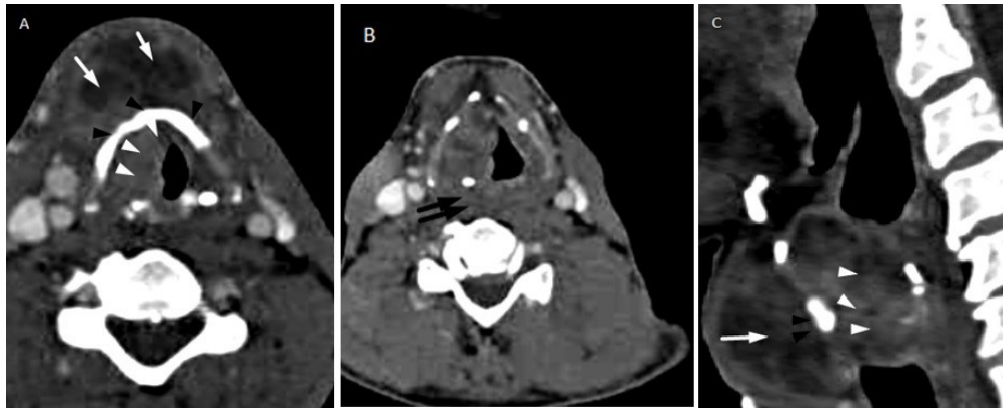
CT imaging features of advanced trans-glottic laryngeal carcinoma. (A) Axial CT image shows a heterogeneous, necrotic soft tissue mass (white arrowheads) involving the right aryepiglottic fold, true and false vocal cords, anterior commissure, and right paraglottic space. The lesion extends into the infraglottic space, causing obliteration of the airway column. (B) Focal sclerosis and erosion of the anterior portions of the thyroid cartilage and bilateral arytenoid cartilages are seen (black arrowhead), indicating cartilage infiltration. (C) The mass infiltrates the pre-glottic space and strap muscles, producing a focal contour bulge with intact overlying skin (white arrows). Posterior extension into the prevertebral muscles on the left side is noted, with loss of a clear cleavage plane (double black arrows).
